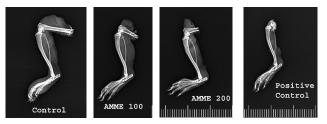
FCA induced Arthritis - Radiography
